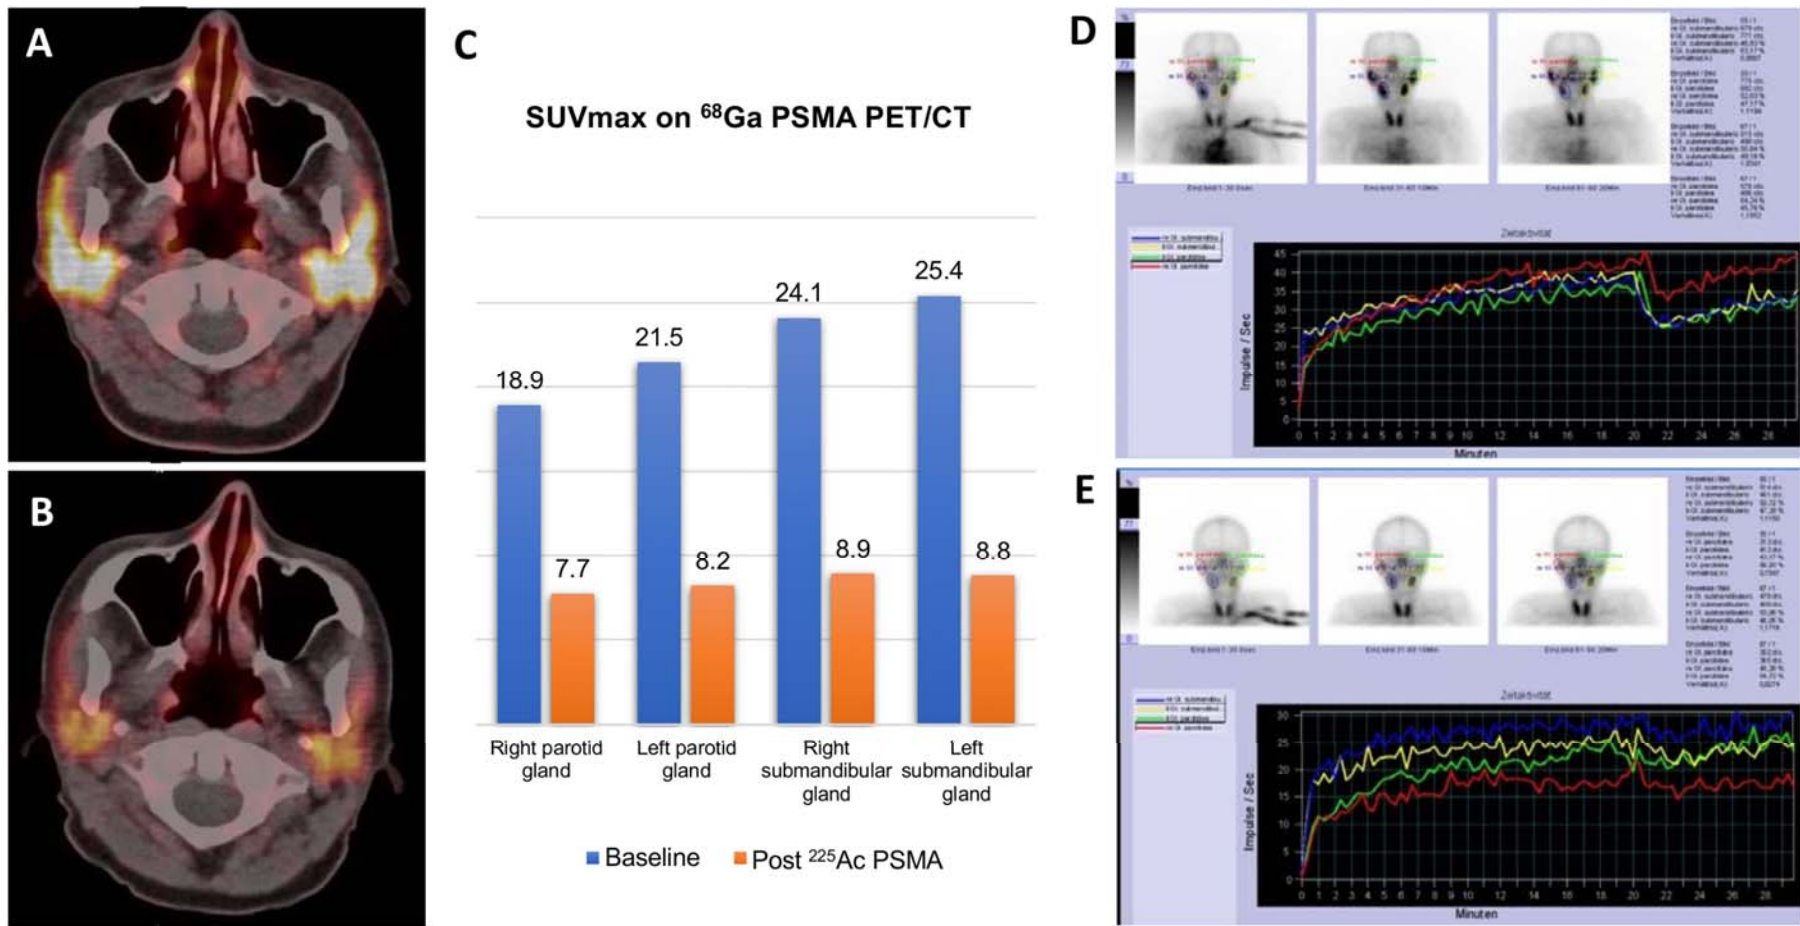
Physiologic tracer uptake is detected in the SG of a 59-year-old mCRPC patient on the pre-therapeutic Ga-68 PET/CT study (A) while PSMA uptake in the SG declines by up to 65 % on follow-up imaging (B,C) after PSMA radioligand therapy using Ac-225. Dynamic SGS demonstrates regular baseline function (D); however, the post-therapeutic study reveals functional impairment despite absence of clinical symptoms of xerostomia (E).
